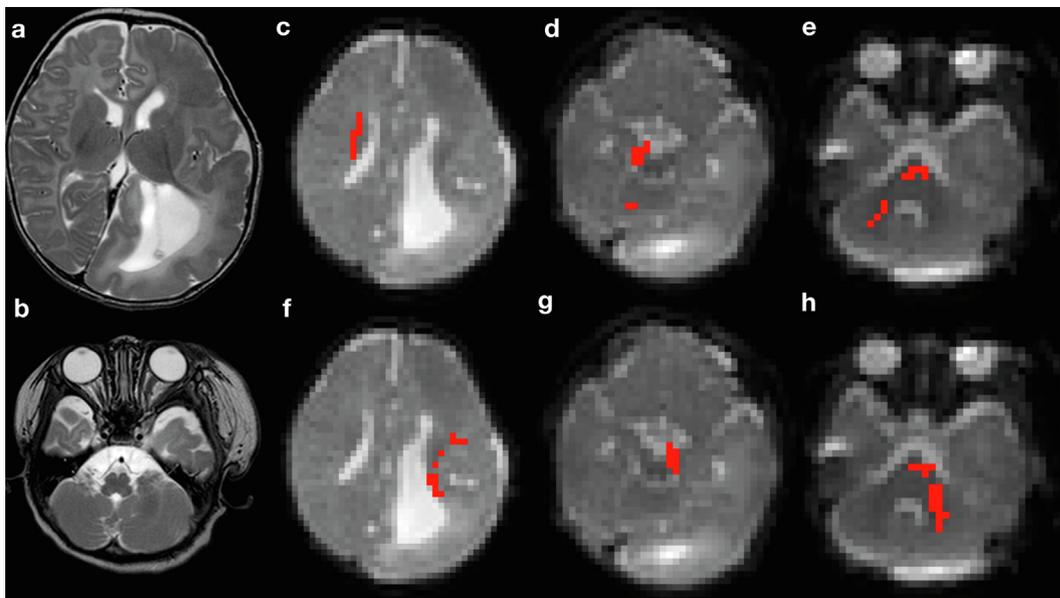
A 3-month-old patient with hemimegalencephaly; unilateral pattern. a,b: T2-weighted images show left hemimegalencephaly with ipsilateral cerebellar enlargement and ipsilateral facial lipomatous overgrowth. c–e: Tractography shows ipsilateral cerebellar distribution of CPC tracts when the ROI is placed in the right cerebral peduncle. f–h: The same on the left side.
